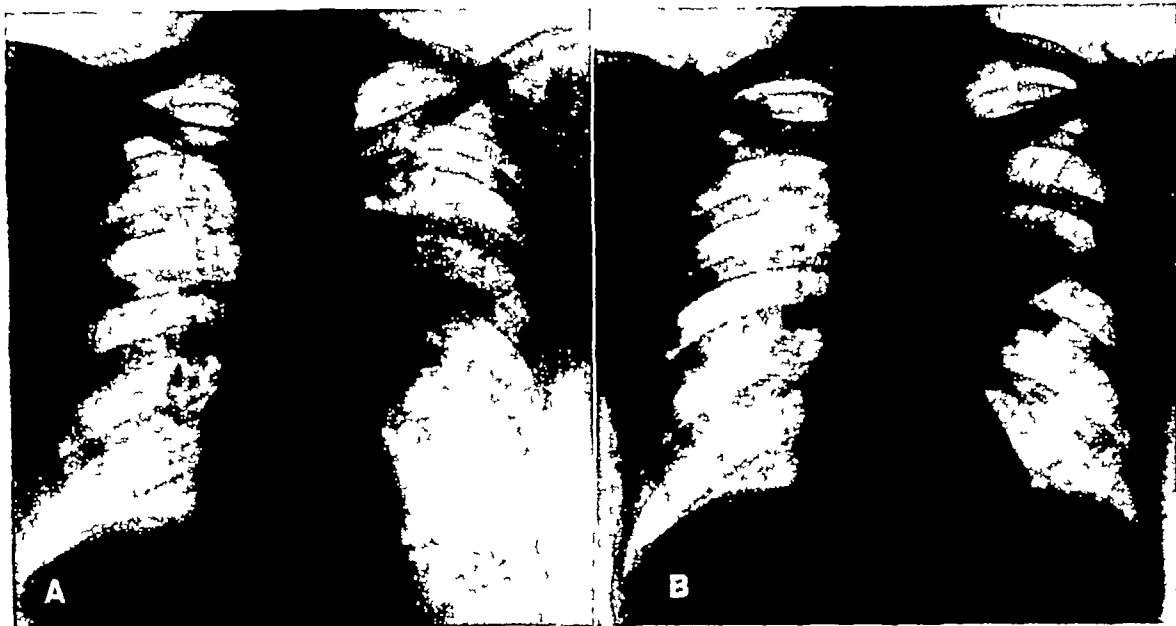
Case 6 A Roentgenogram showing a hilar density in the left lung field. Fluid levels are present in the second and fourth anterior interspaces. The cavitary form of bronchogenic carcinoma may present a similar appearance.
